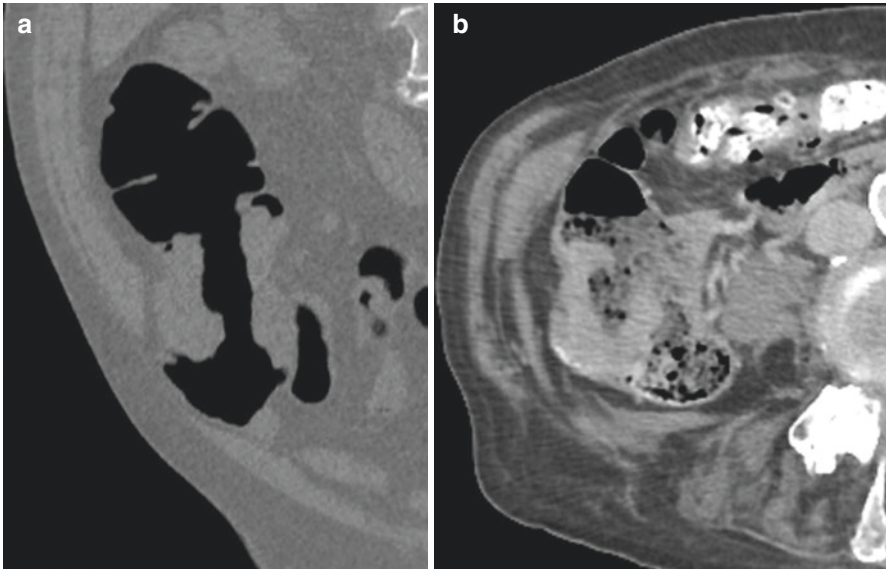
(a) CT colonoscopy finding of colon cancer. (b) Fecal tagging CT finding of colon cancer
